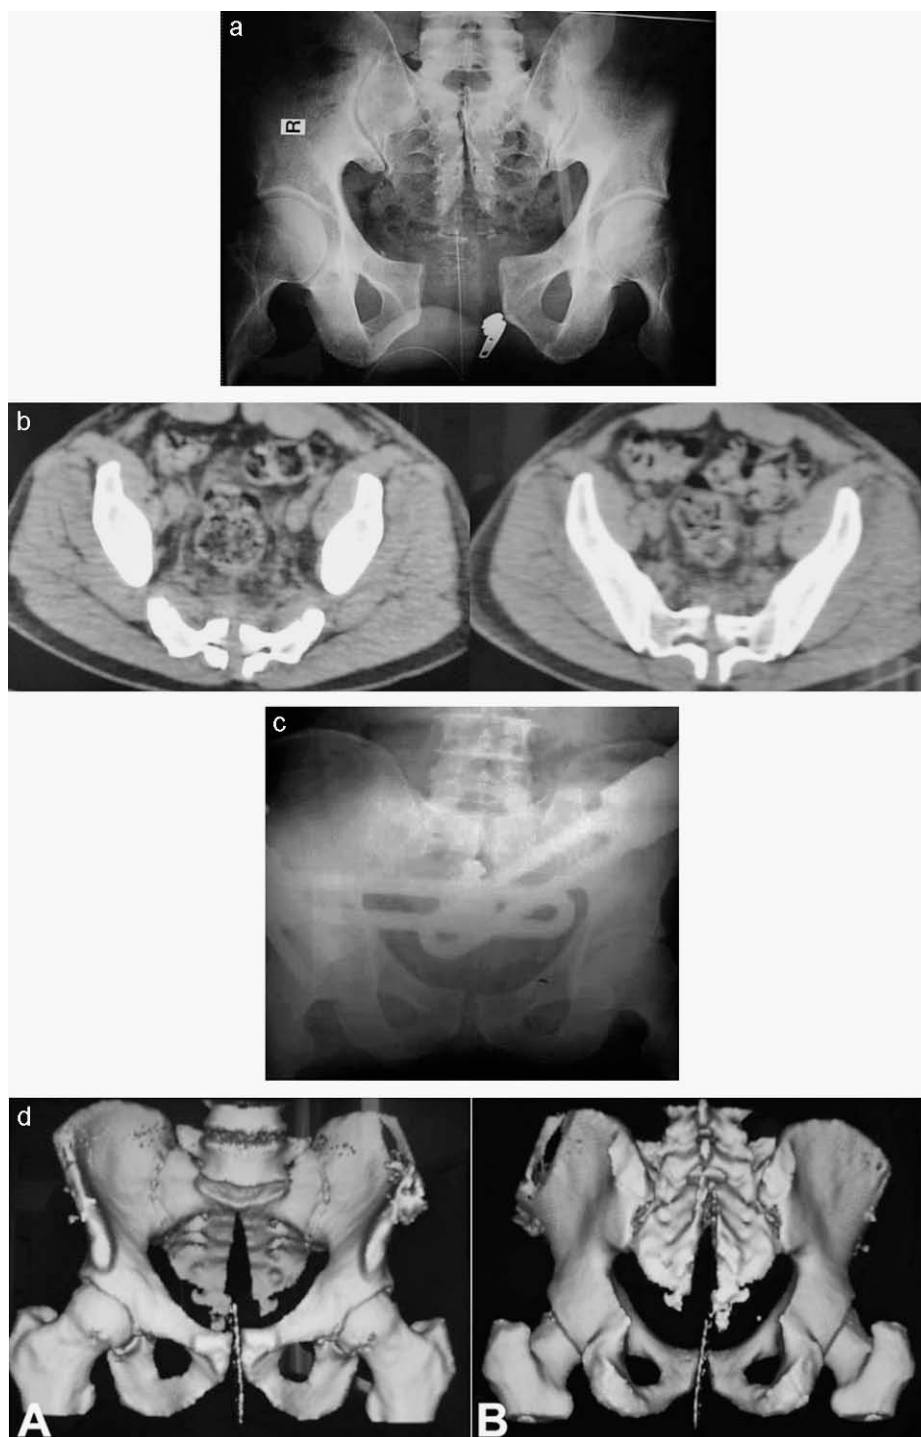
a) Initial antero-posterior X-ray of the pelvis showing diastasis of the pubic symphysis and a mid-sagittal sacral fracture b) Initial CT of the pelvis revealing fracture of the sacrum, c) Antero-posterior X-ray of the pelvis after stabilization of the pelvic ring with the external fixator. d) Post-operative 3D CT (A) anterior and (B) posterior of the pelvis with 3D reconstruction.
